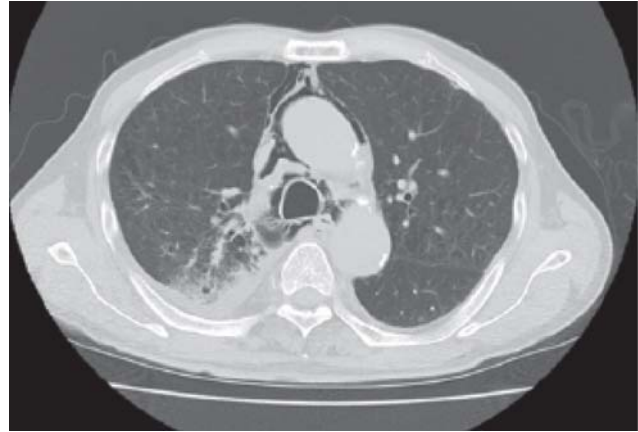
Computed tomography of the chest 1 day after the bronchoscopic examination. Mediastinal emphysema and subcutaneous emphysema are evident.
